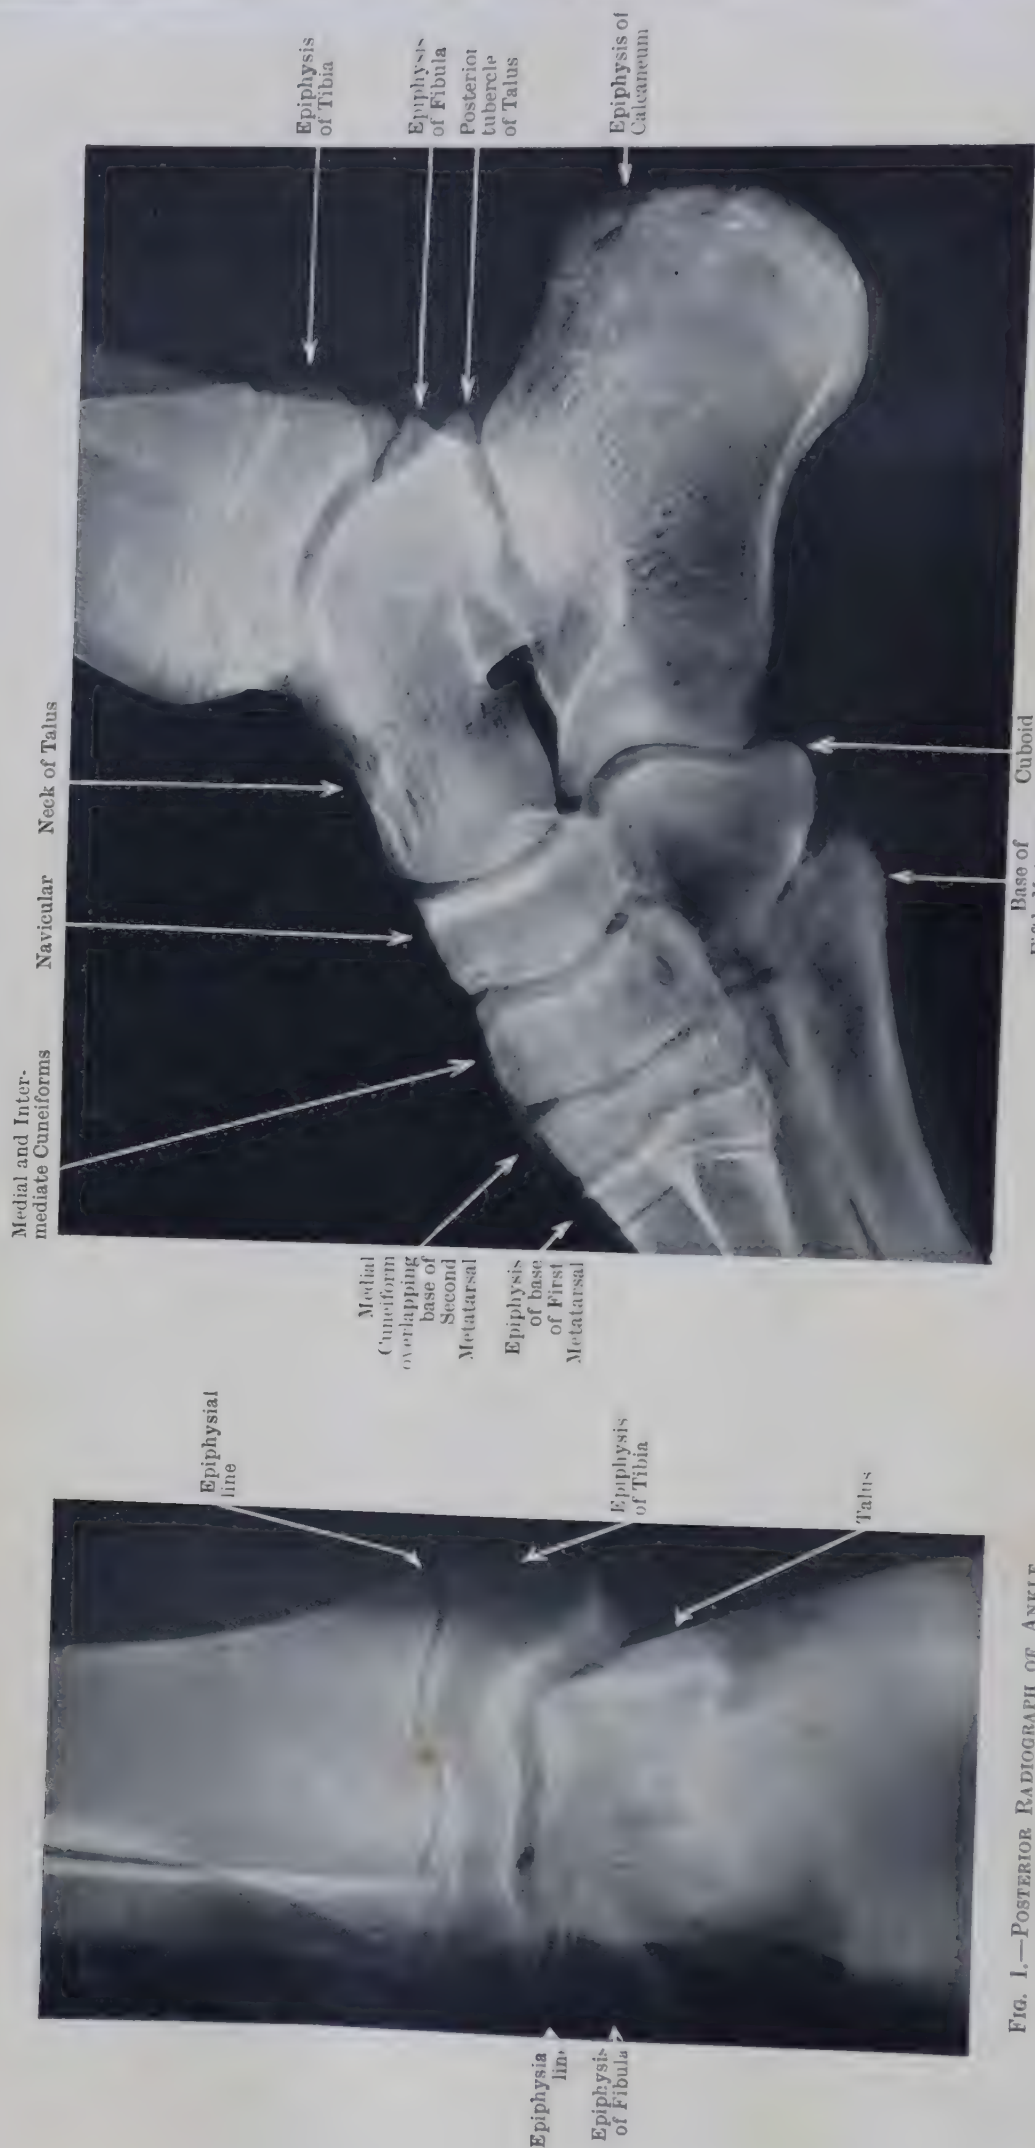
POSTERIOR RADIOGRAPH OF ANKLE OF GIRL AGED 12.
